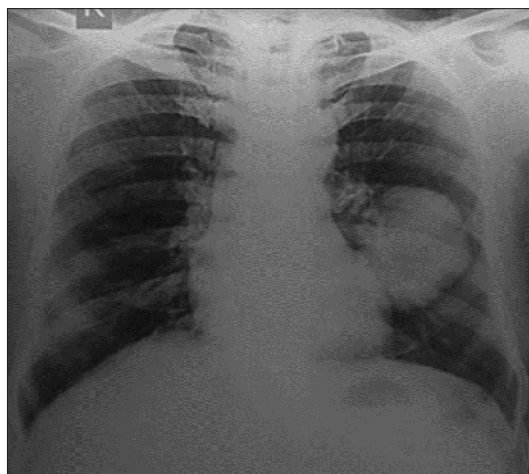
Chest X-ray PA view showing mass lesion in the left lower lobe of the lung
